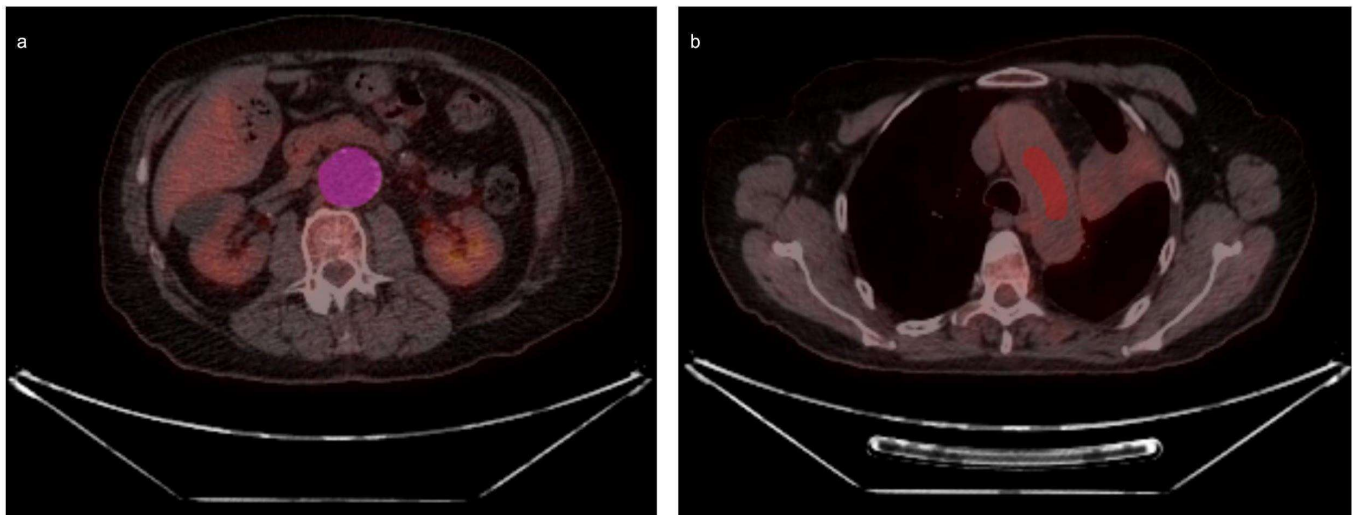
Axial fused [18F]FDG PET-CT images demonstrating a two-dimensional section of the three-dimensional volume of interest. (a) Volume of interest drawn around the abdominal aortic aneurysm. (b) Volume of interest drawn within the aortic arch blood pool.
